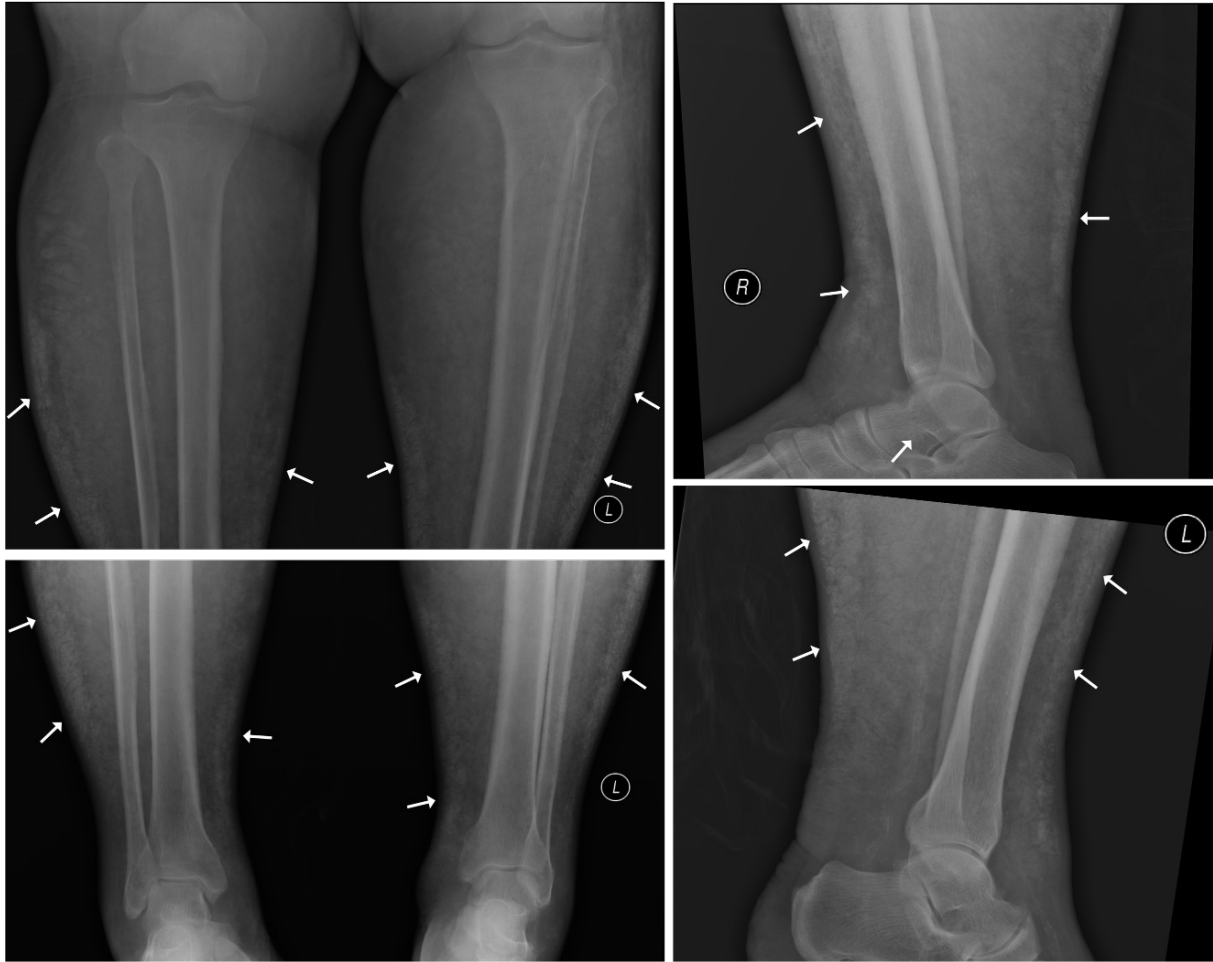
Radiographs of the patient's bilateral lower limbs show extensive subcutaneous fine linear calcific densities (white arrows), suggestive of calcific uraemic arteriopathy.
